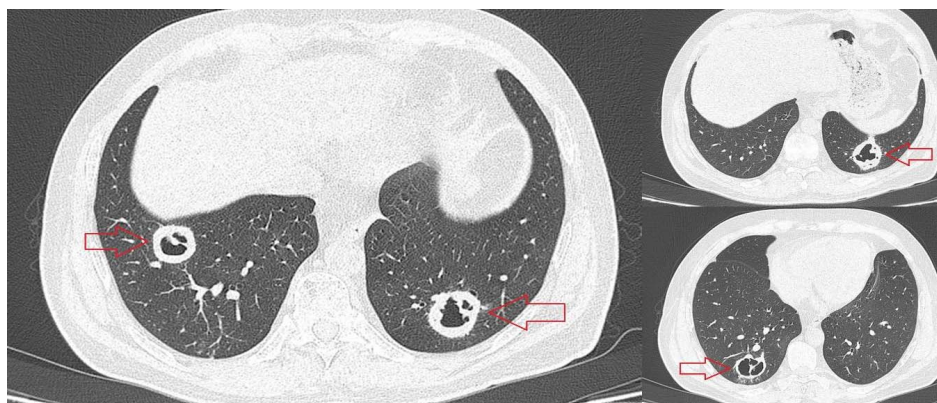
CT scan - Cavitary images in the bilateral lower lobes
